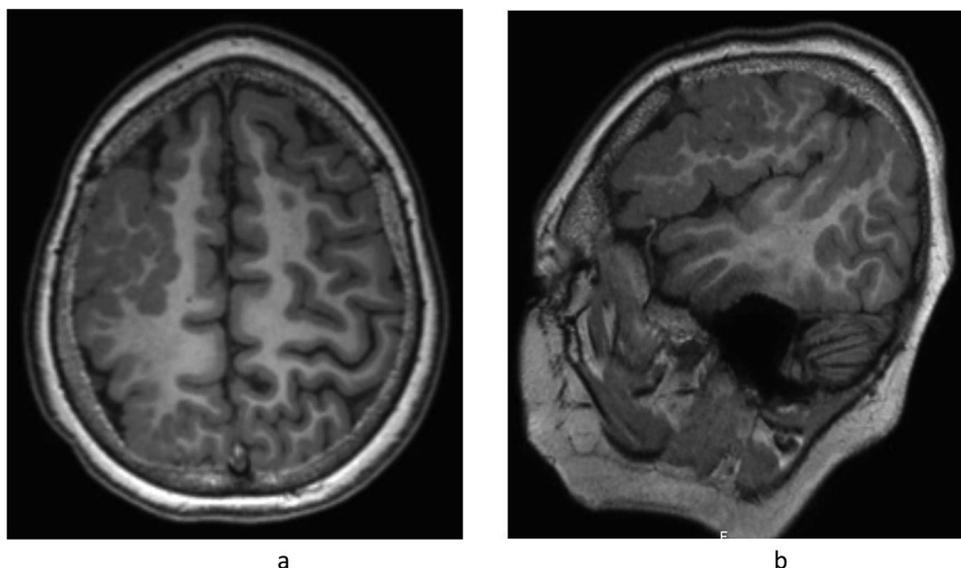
MRI scan, T1 weighted sequence in axial (4a) and sagittal view (4b) showing right hemispheric polymicrogyria (patient 16).
